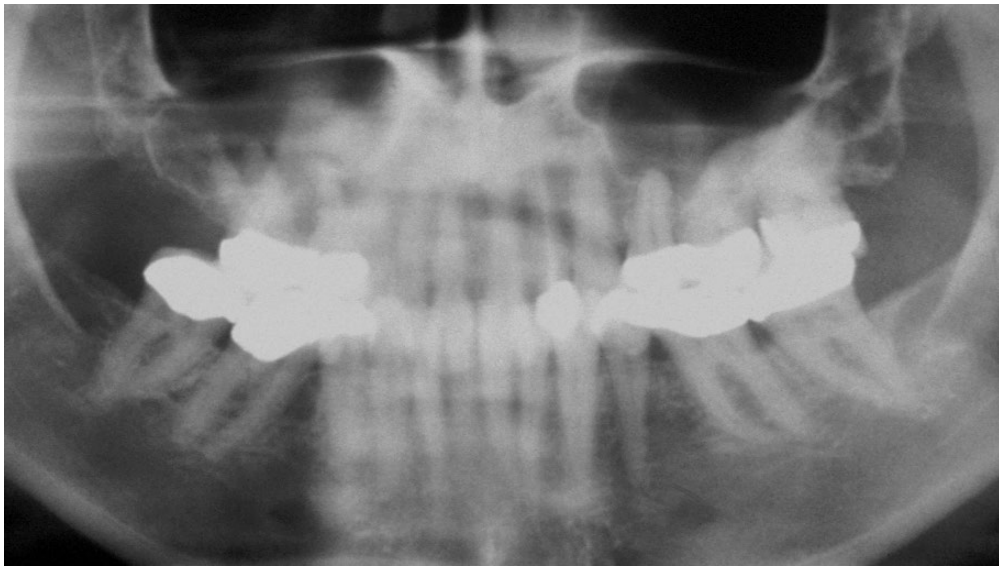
(D) Pre-op panoramic radiograph. Notice patient has a dental history with multiple restorations and endodontic treatment of tooth #10.
